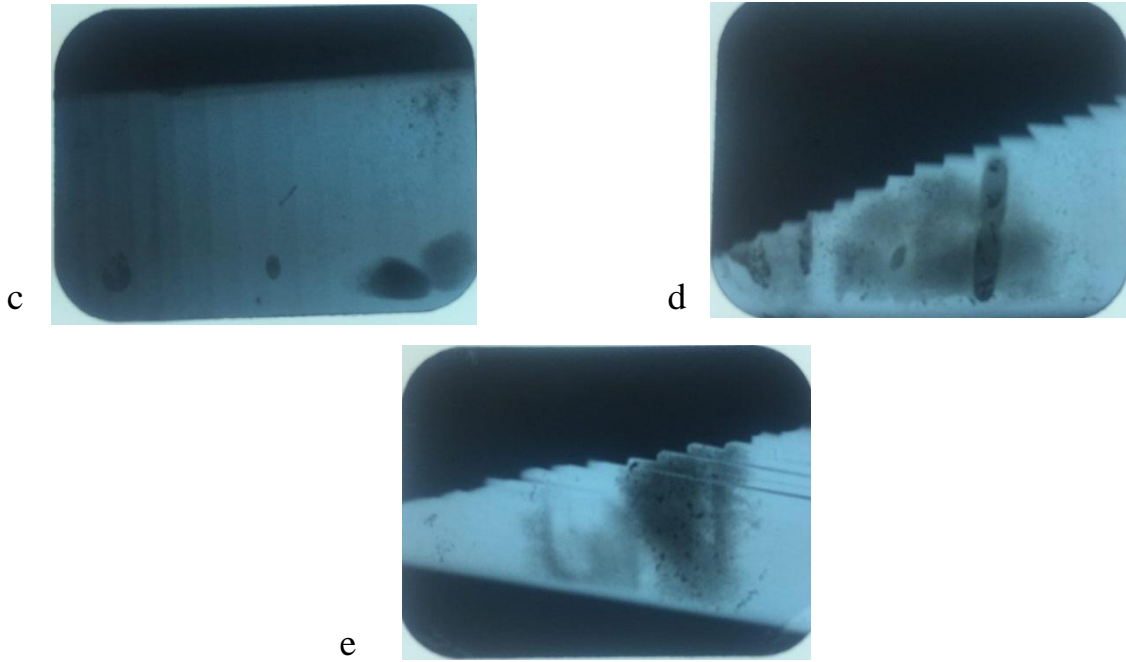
occlusal radiograph tech.
